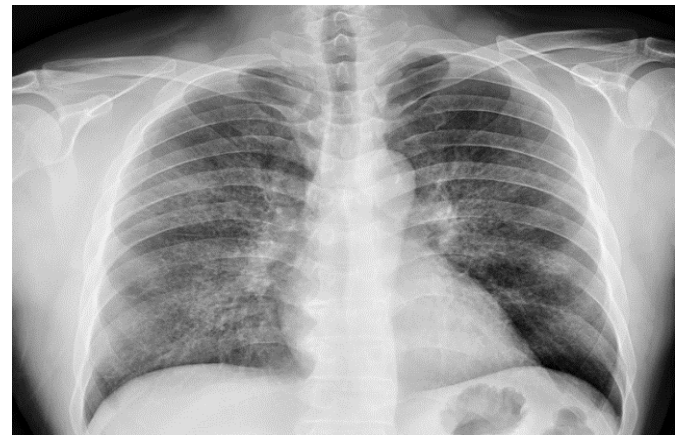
Chest radiography and lung computed tomography findings in interstitial pneumonia
